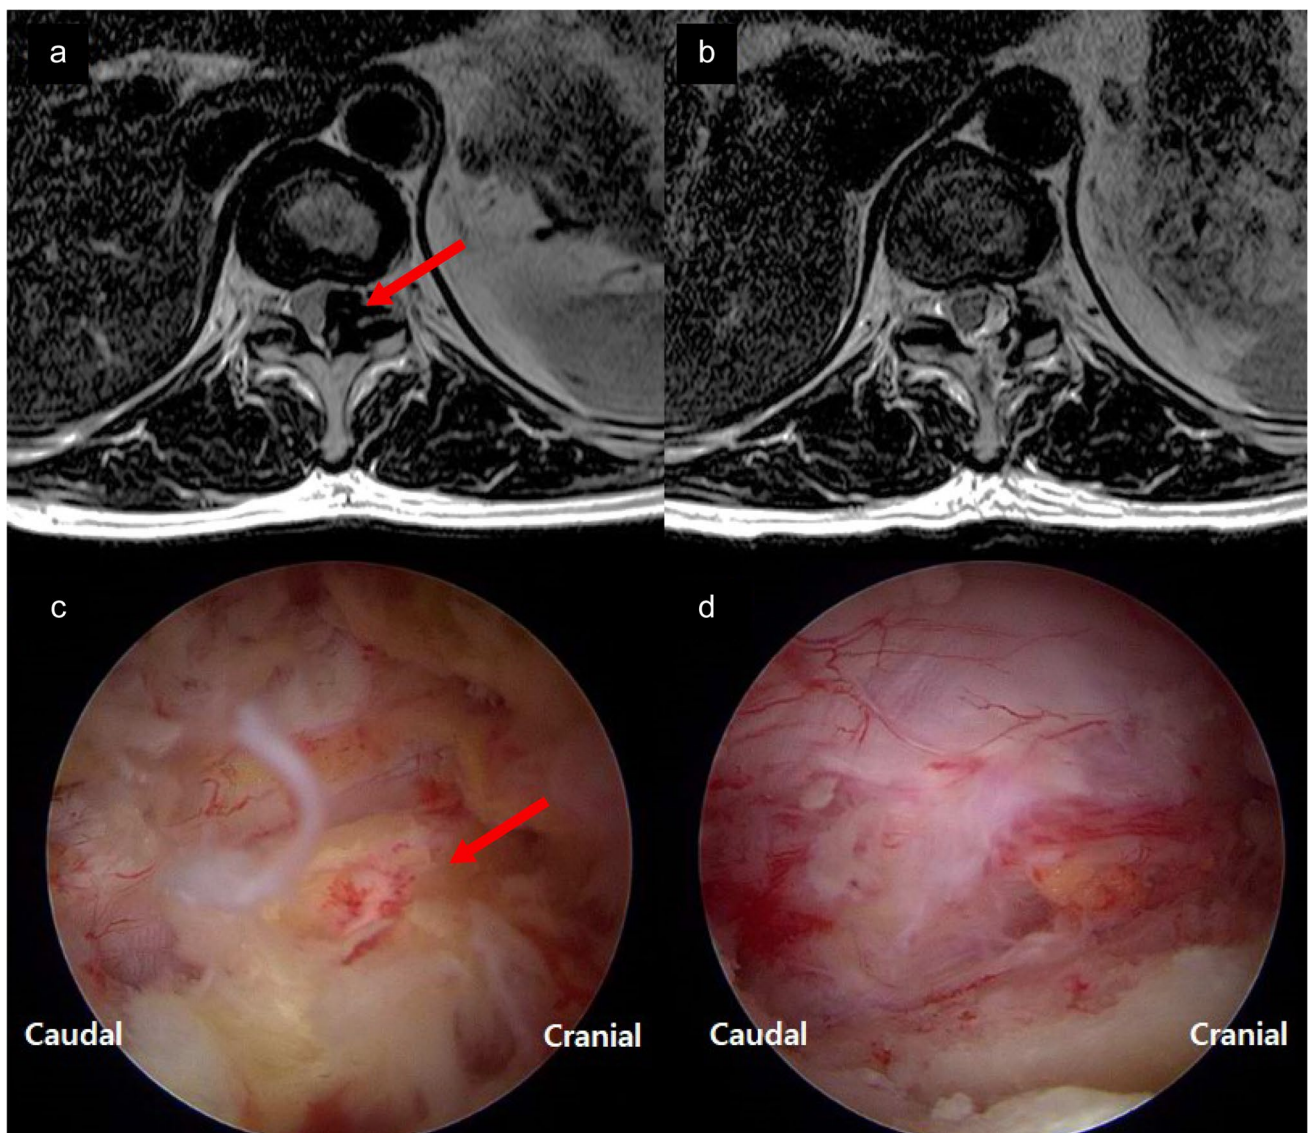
Postoperative well-decompressed spinal cord. Preoperative (A) and postoperative (B) magnetic resonance imaging and preoperative (C) and postoperative (D) endoscopic images. Red arrow: ossification of the ligamentum flavum
